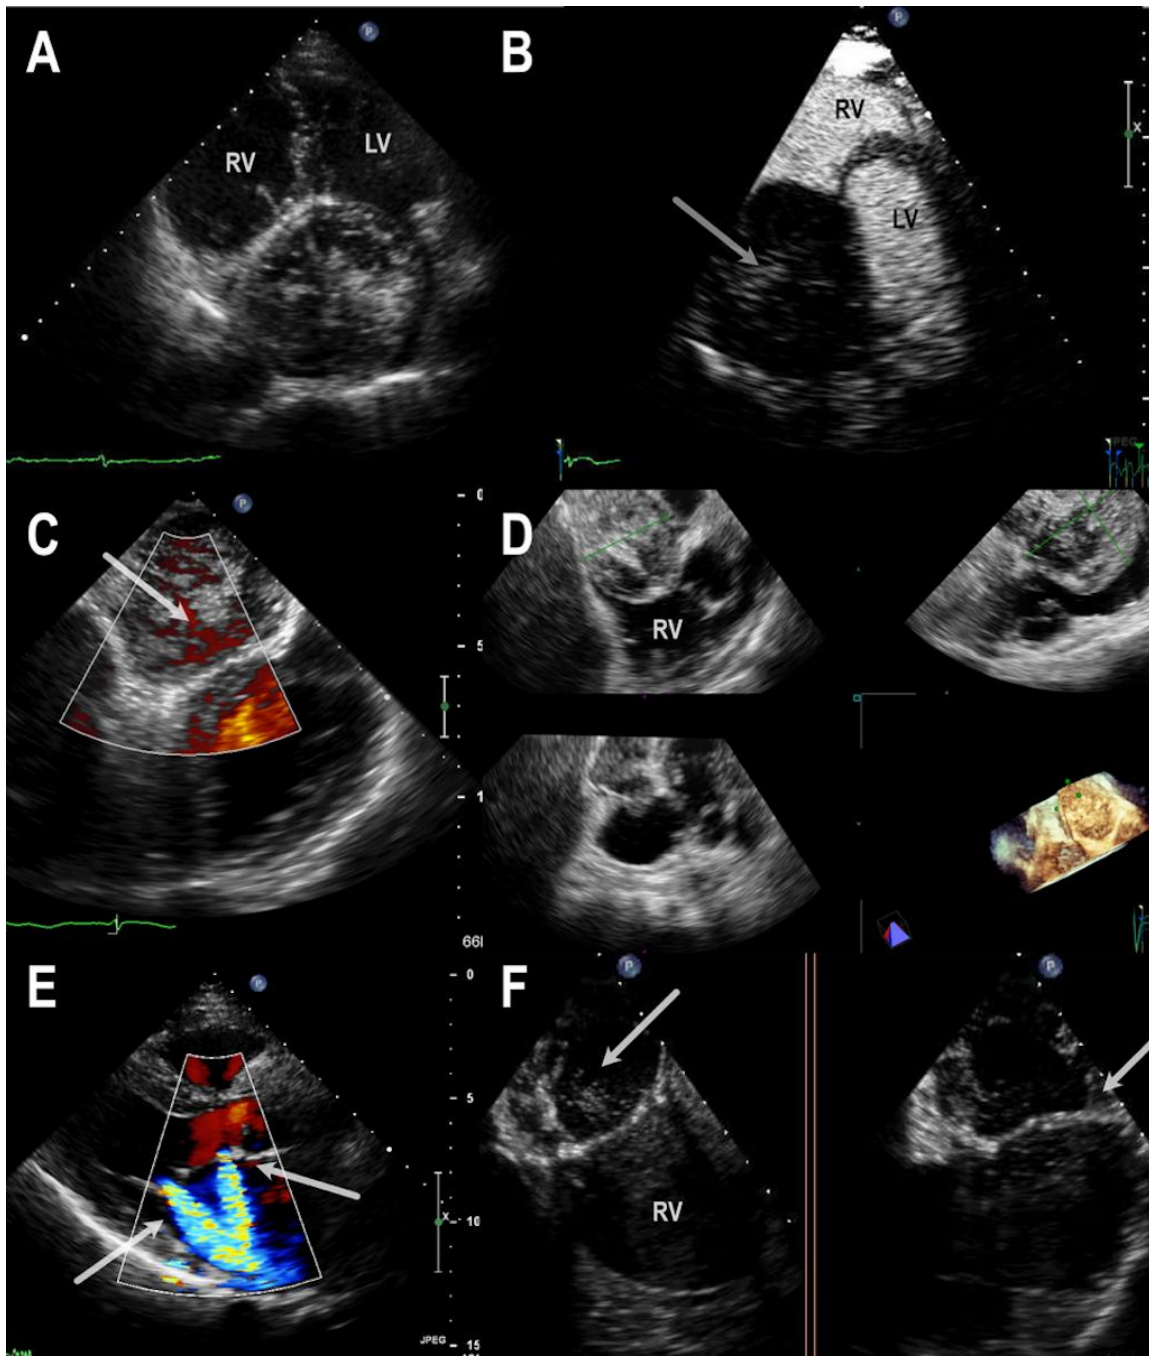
A. A 2D TTE 4-chamber apical view of the atrial tumor B. Contrast TTE revealing intra-tumor flow C. TTE Doppler exam revealing intra-tumor flow D. A 2D and 3D TEE view of the atrial tumor E. TTE Doppler exam of post-resection mitral regurgitation caused by basal A2 segment tear. F. Communication between the remaining cavity after tumor resection and the left atrium confirmed by contrast echocardiography
